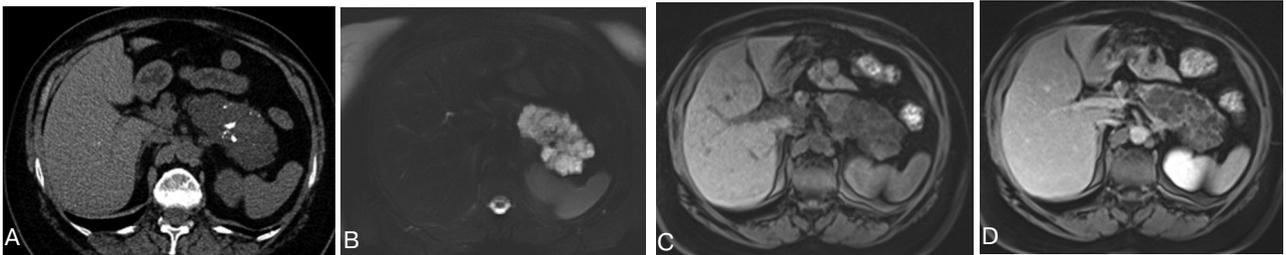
Serous cystadenoma. A. CT scan shows a heterogeneous hypodense lesion with lobulated outlines and central calcifications in the body and tail of the pancreas. The lesion has the appearance of a solid mass with numerous small cysts. B. T2-weighted MR image shows the internal morphologic features of the lesion, with high-signal-intensity microcysts being clearly distinguished from the dark central calcifications. C. T1-weighted MR image shows the heterogeneously hypointense lesion with multiple septations and lobulated contour. D. Gadolinium-enhanced T1-weighted MR image shows the lesion has low signal intensity with rim enhancement and enhancing fine internal septations.
